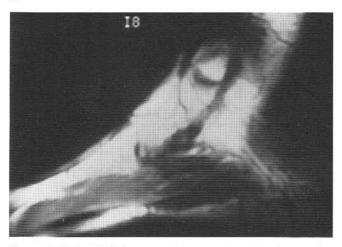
Sagittal MRI demonstrating attenuation of tendon correlating with point of maximum tenderness.
